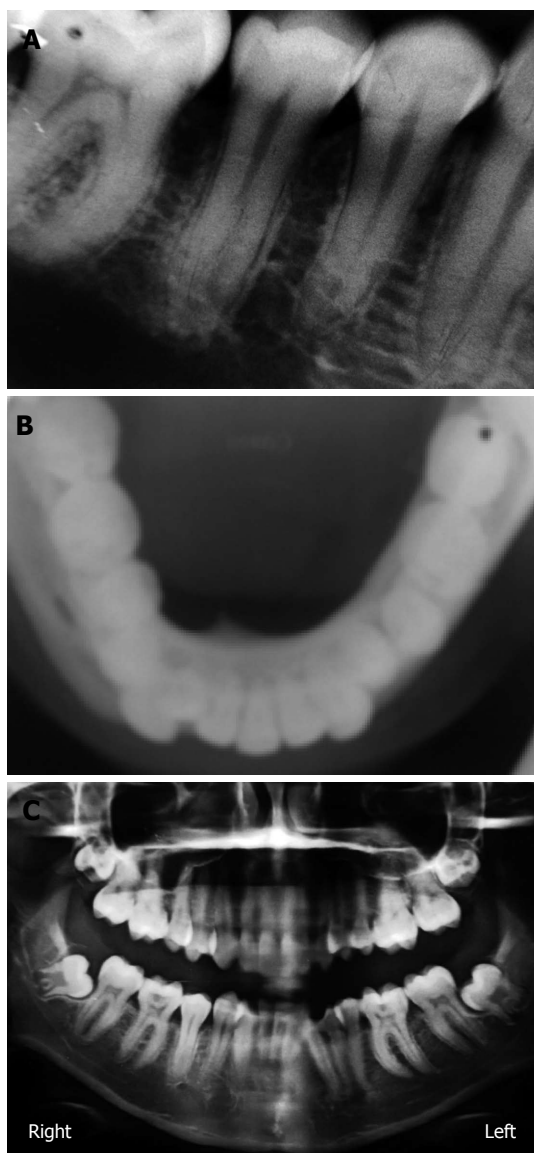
Non involvement of bone. A: Intra oral periapical radiograph; B: Maxillary occlusal radiograph; C: Ortho pantomo radiograph.
